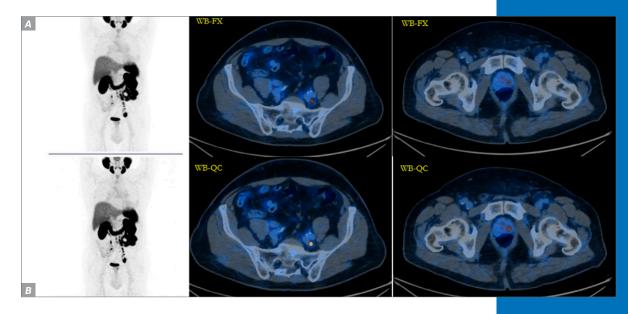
68-Gallium PSMA images acquired on Discovery MI 3 rings system and reconstructed with PSF OSEM reconstruction (a) and Q.Clear reconstruction (b) demonstrating Q.Clear produces sharper images with better visualization of small lesions in this specific case.
